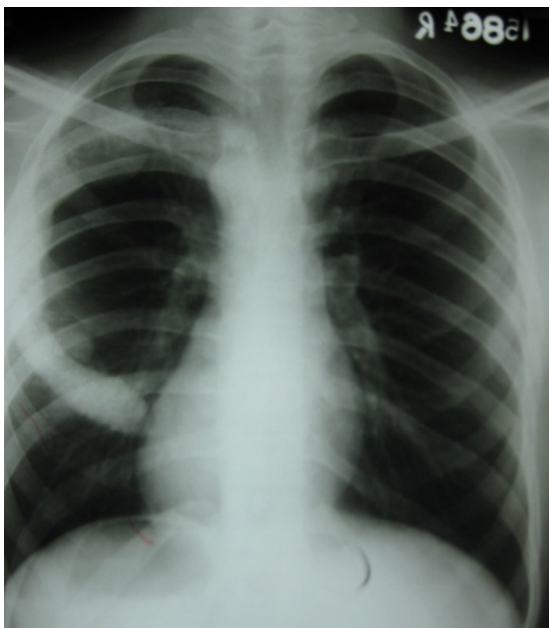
Case 2 X-Ray Chest showing involved sclerotic rib.
